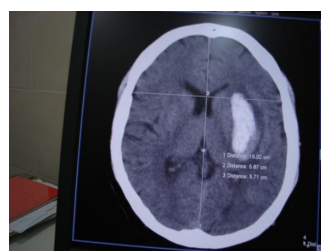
Noncontrast axial CT scan of brain of 63 years male patients showing spontaneous intracerebral haemorrhage with mass effect measured using septum pellucidum shift 1.6 mm. the GCS score of the study subject was 7.
